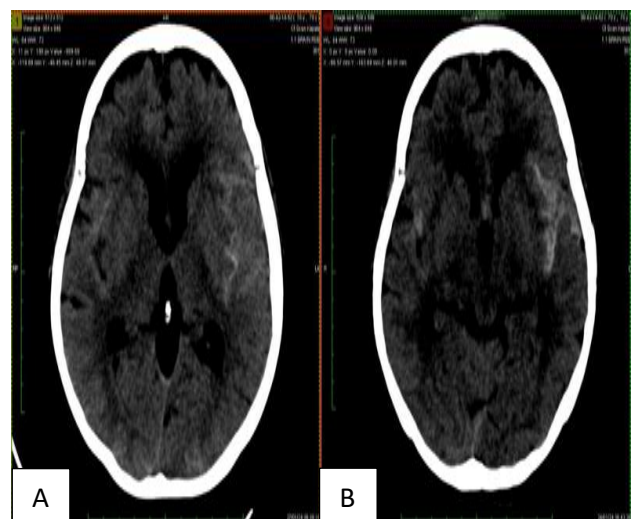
(A and B): Follow up of brain CT scan at 3 days of follow up following the onset of subarachnoid hemorrhage.
